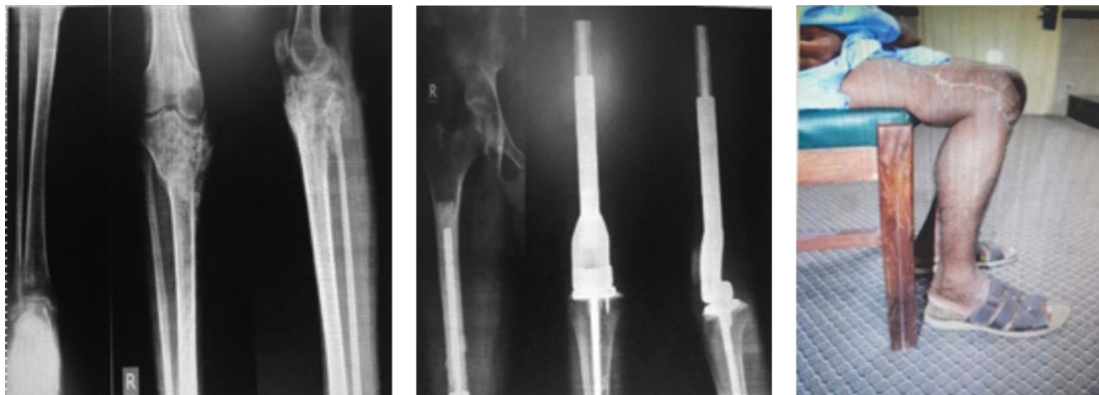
Pre operative xrays,post operative xray and clinical picture of right Osteosarcoma tibia treated with Locally made custom-built fixed hinged knee prosthesis.
